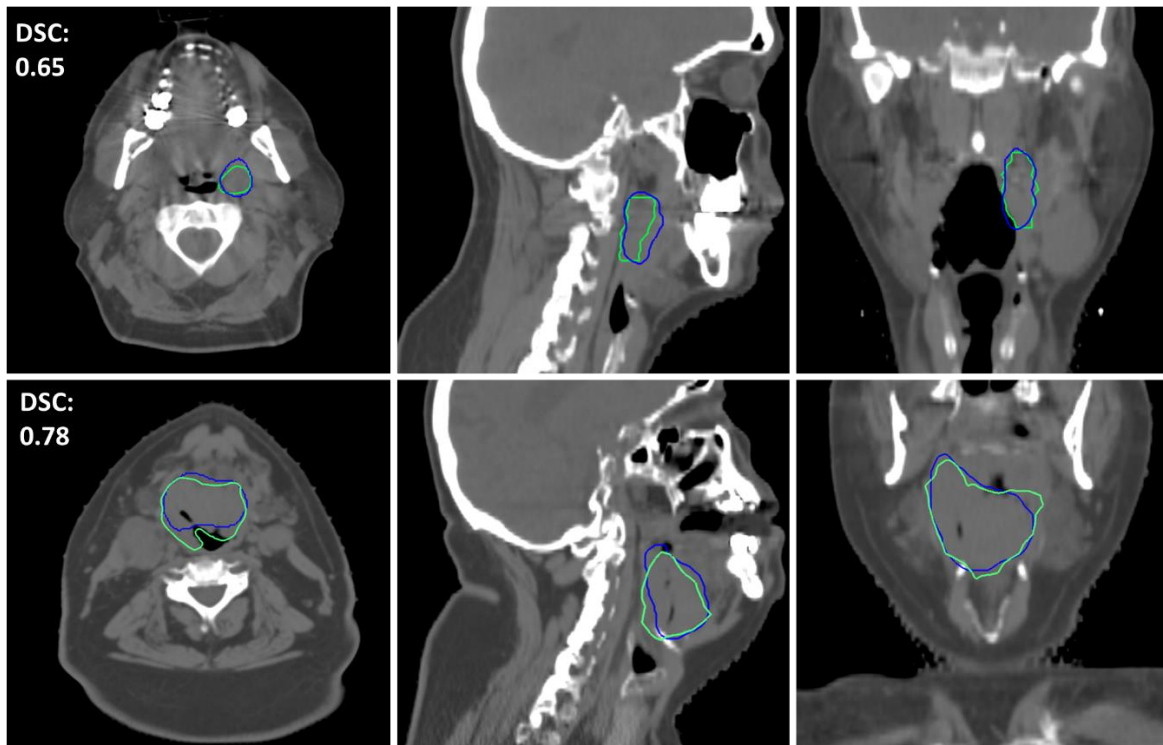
Examples of two cases with large and small tumor sizes. The first row shows the axial, sagittal and coronal views of a patient with tumor volume of 6.6 cm³, and the DSC for the auto-generated GTV is 0.65. The second row shows a patient with tumor volume of 57.3 cm³ with DSC of 0.78. Green is the GTV delineated by physician; Blue is the GTV contour auto-generated based on CT/PET/MR (in Stage 2).
